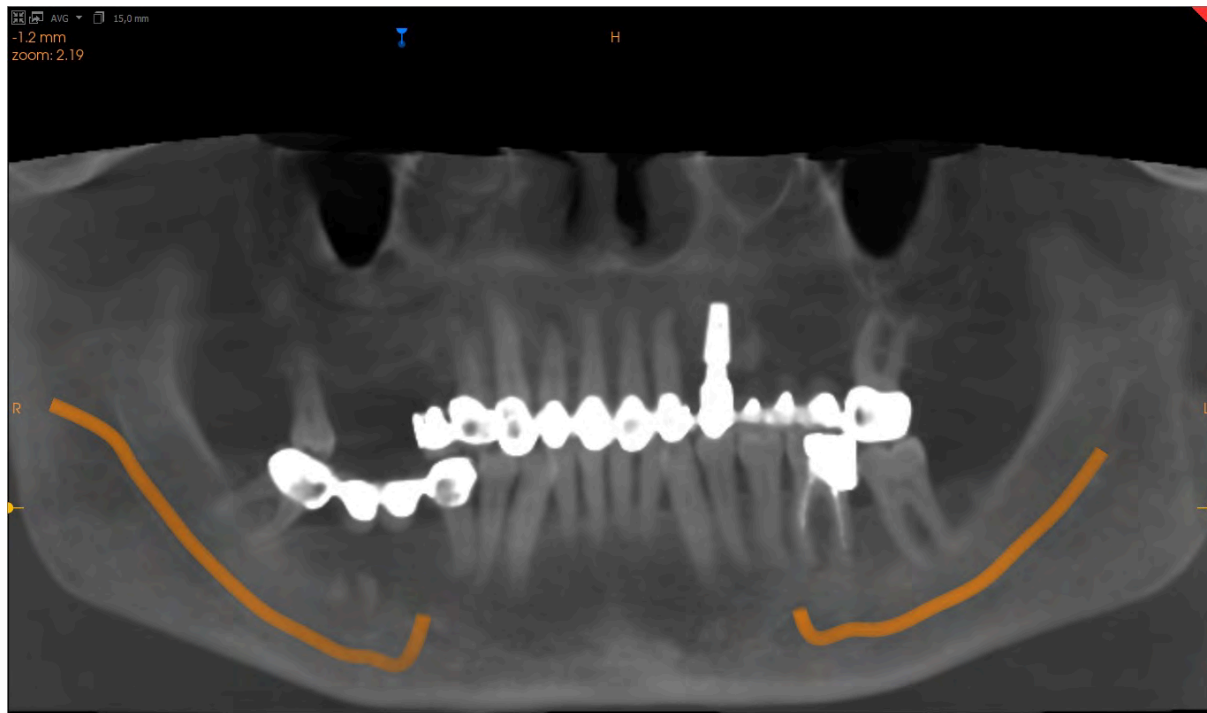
Panoramic radiograph
